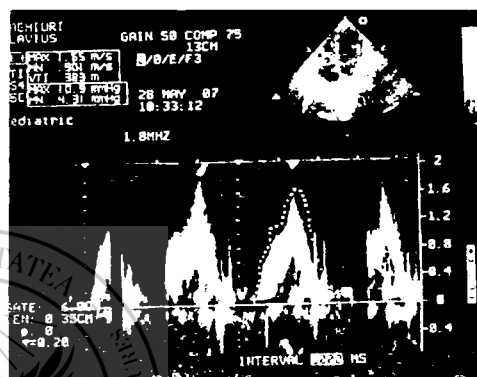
Apical four chamber, spectral Doppler - large tricuspid stenosis
